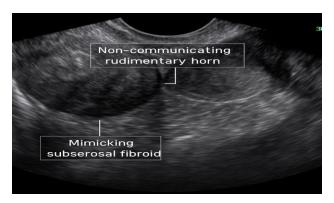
Transvaginal ultrasound image showing a non-communicating rudimentary horn mimicking a subserosal fibroid in a patient with chronic dysmenorrhea.
